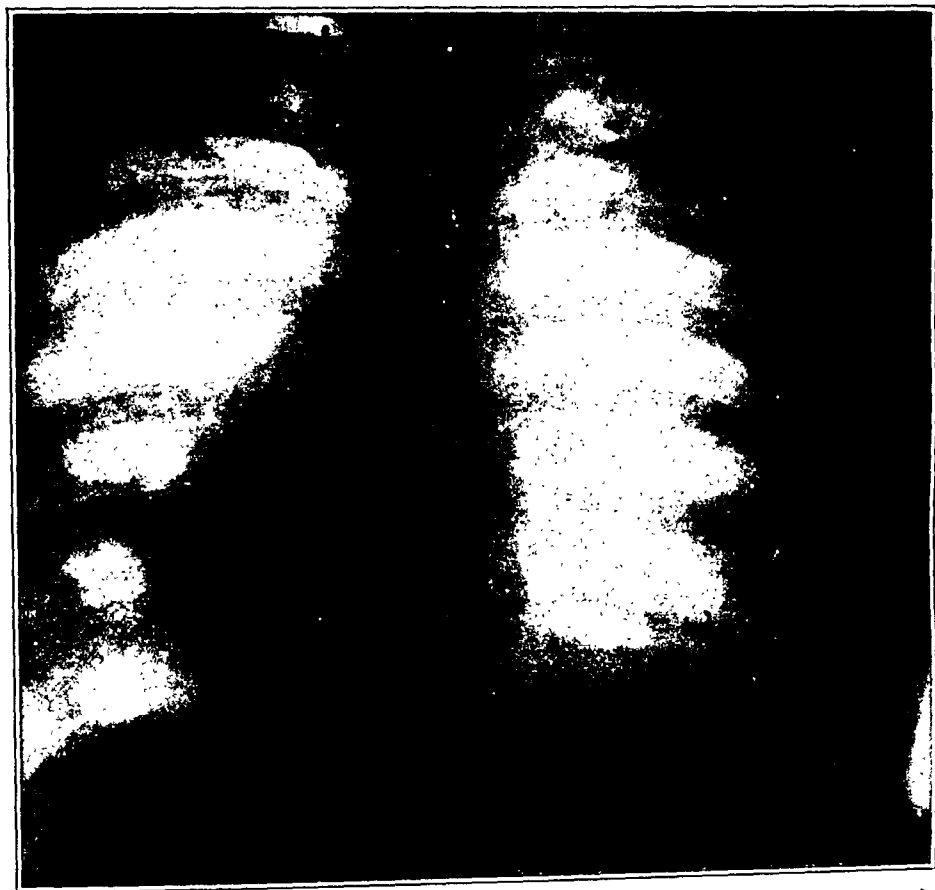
Case I. Roentgen-ray plate made, December 31, 1923, confirming the finding of evidence of sarcoma metastases in the previous plate of December 7, 1923.
